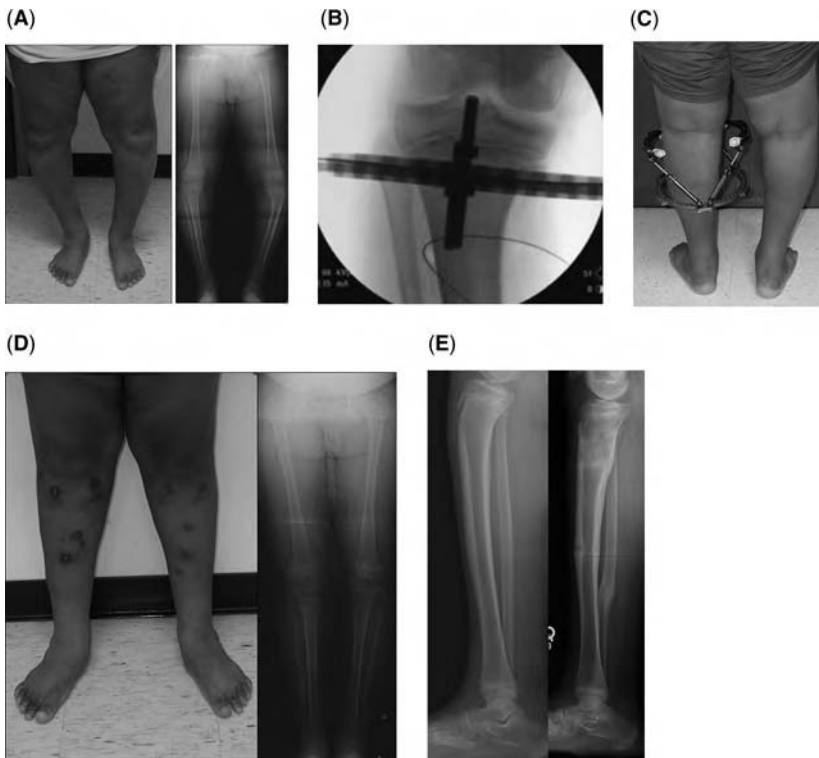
(A) Clinical photo and standing anteroposterior (AP) radiograph of a 12-year-old obese male with bilateral late onset Blount's disease. He underwent staged realignment of both legs few months apart. (B) Intraoperative fluoroscopic AP view of the proximal tibia after centering of the proximal ring and percutaneous passage of the Gigli saw at the level of the planned osteotomy site. (C) Clinical photograph during the consolidation phase of realignment of the left sided deformity. Note the posterior opening of the proximal ring to allow knee flexion. (D) Clinical and radiographic appearance following bilateral staged tibial osteotomies with gradual correction. The mechanical axis has been restored to normal. (E) Pre- and postoperative lateral view radiographs of the tibia showing adequate correction of the proximal tibial procurvatum deformity.
